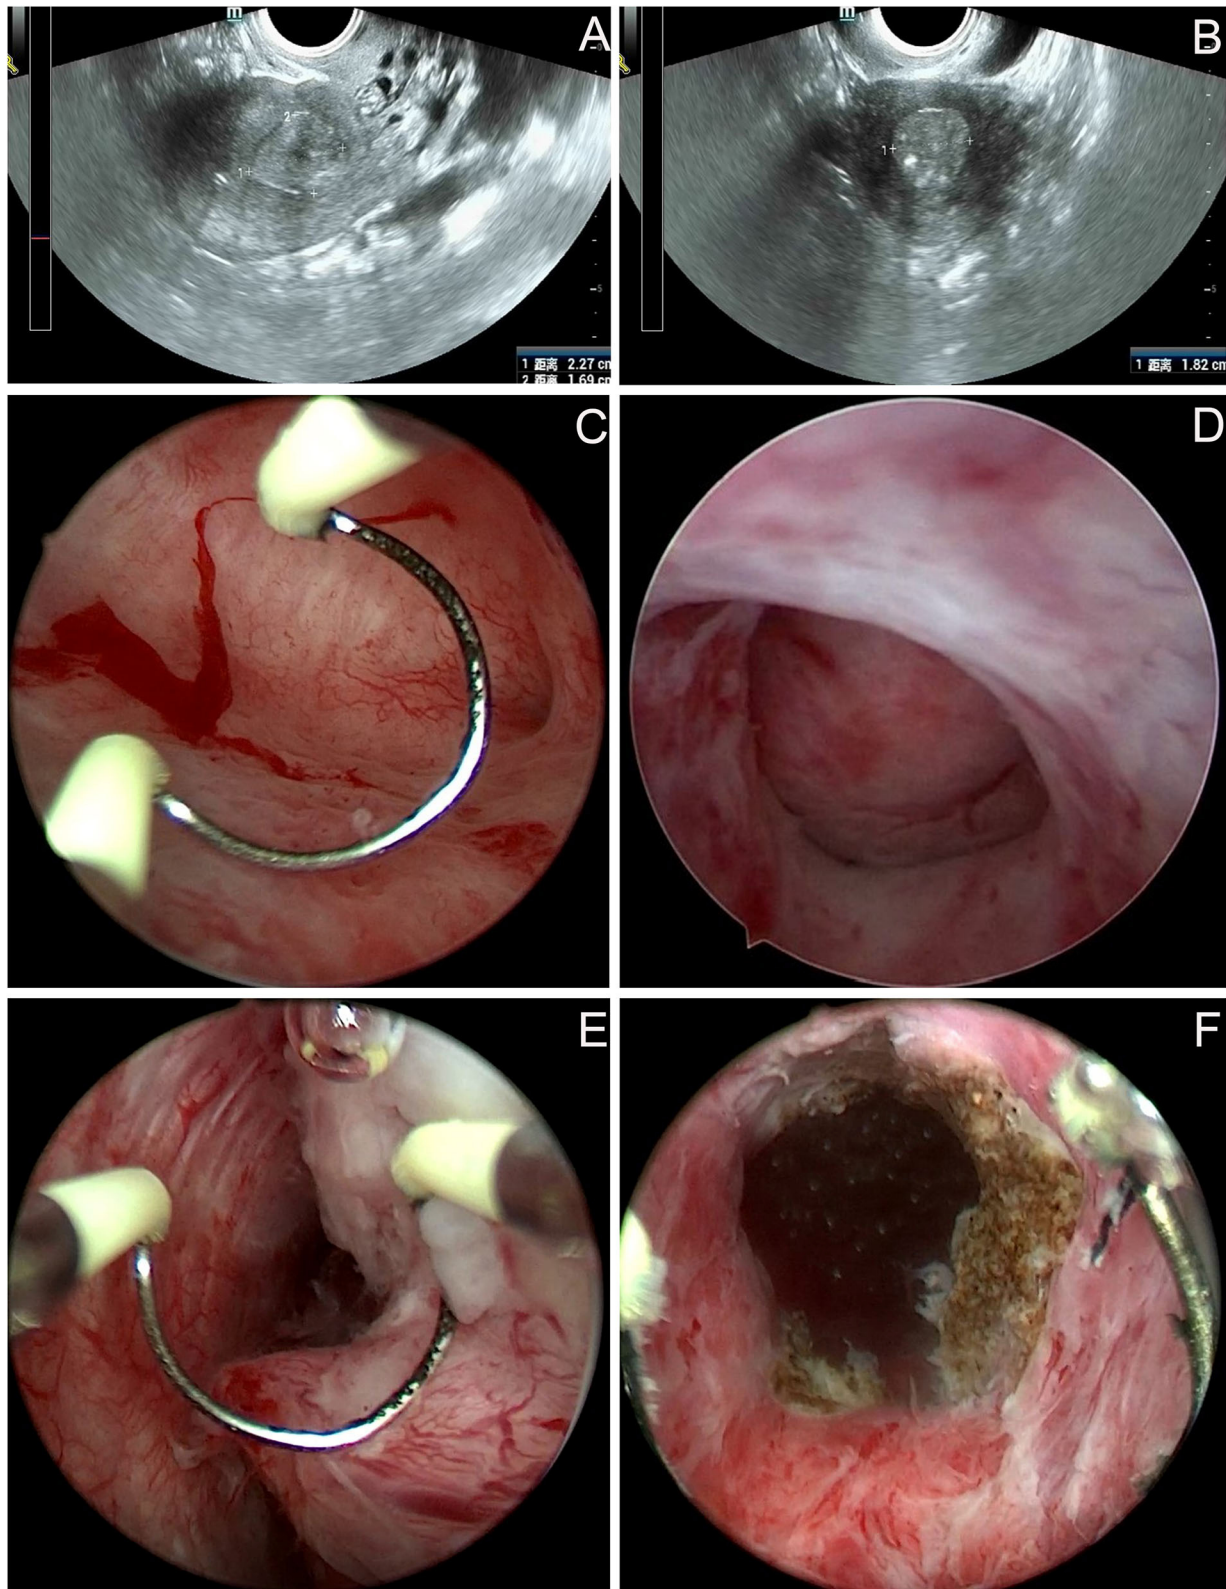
Imaging findings of the patient before and during the first operation. (A,B) Pelvic ultrasound: a mass around $2.3 \times 1.8 \times 1.7$ cm was seen in the lower part of uterine cavity. The internal echo was uneven, and the boundary was clear. (C–F) Hysteroscopy: a mass with a size of about 2.5×2.0 cm was seen at the left anterior wall close to the internal os. The local shape was irregular, the surface contained thickened blood vessels. The tumor was removed using a circular electrode, the boundary between the attachment position of tumor and cervical tissue was unclear.
